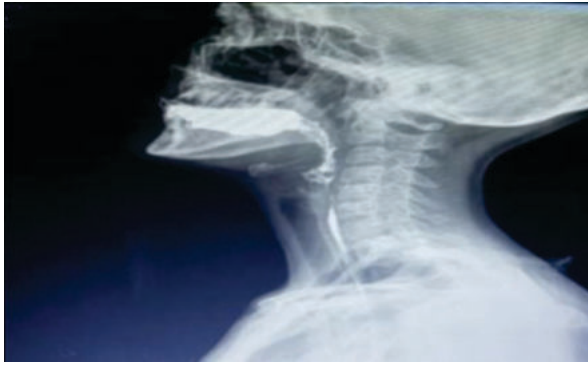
Lateral Neck Xray Suggestive Of Esophageal Stricture.
